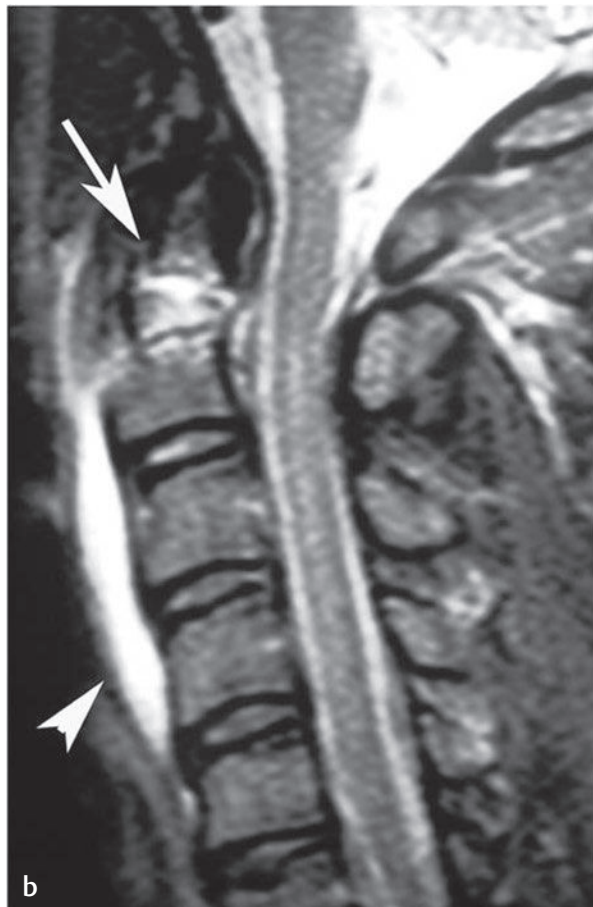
These sagittal (a) T1-weighted and (b) T2-weighted images of a type-II odontoid fracture (*arrow*). Note the osseous and paravertebral edema or hematoma (*arrowhead*), which indicates an acute or subacute fracture.
